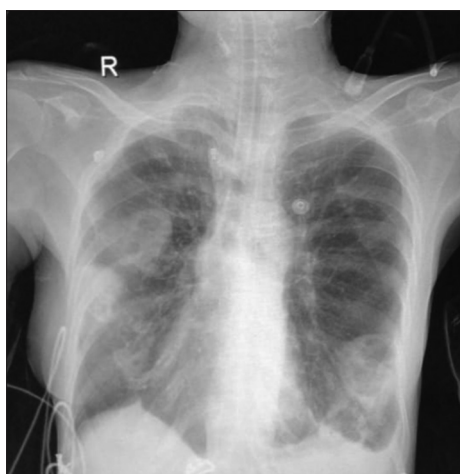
Chest X-ray showing bilaterally multiple cavitating lesions
